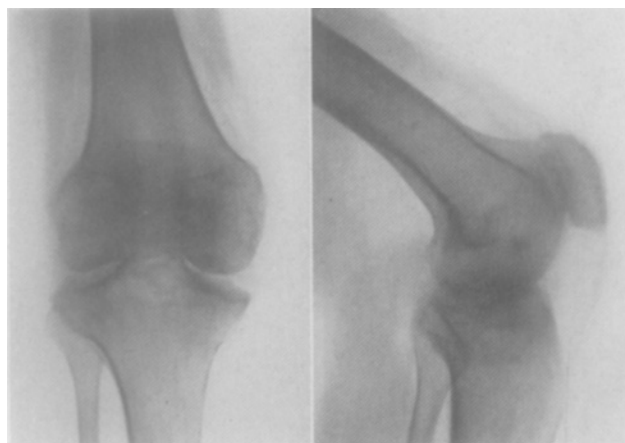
Case 4: roentgenograms of right knee before operation.
